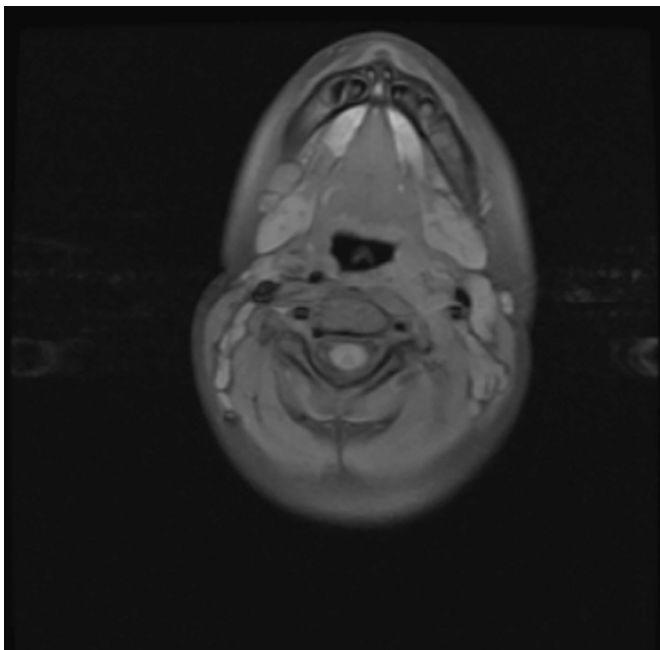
MRI neck with contrast, performed on postoperative day 14. Selected fat saturated T₁-weighted axial image through the neck demonstrates soft tissue thickening and infiltration of left parapharyngeal space and carotid space adjacent to distal extracranial internal carotid artery. MRI, magnetic resonance imaging.
